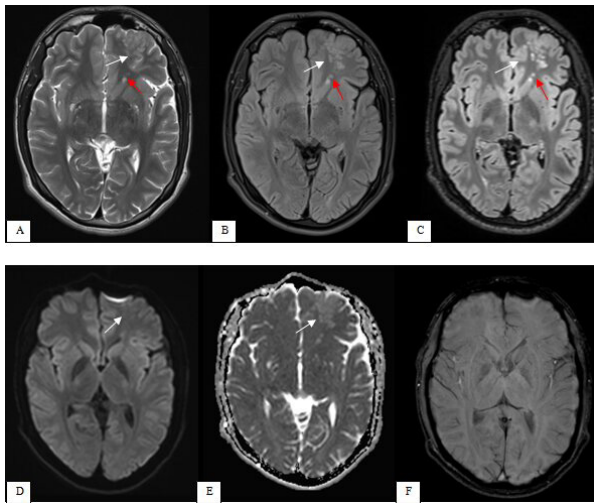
Axial T2w (A), Flair (B), Flair 3D reconstruction (C) images showing a left frontal intraaxial subcortical lesion consisting of multiple, well margined coalescent hyperintense nodules (A,B,C, white arrows). Note the lower signal intensity of the lesions in comparison to CSF on T2w images (A) and the absence of surrounding white matter hyperintensity on T2w/Flair images (A,B,C). Axial DWI (D) and ADC mapping (E) showing no restricted diffusion (D,E, arrows). Axial SWI (F) image shows no blooming. Note the superficial subcortical localization of the lesions following the gyral contour with extension to the deeper white matter areas (A,B,C, red arrow)
